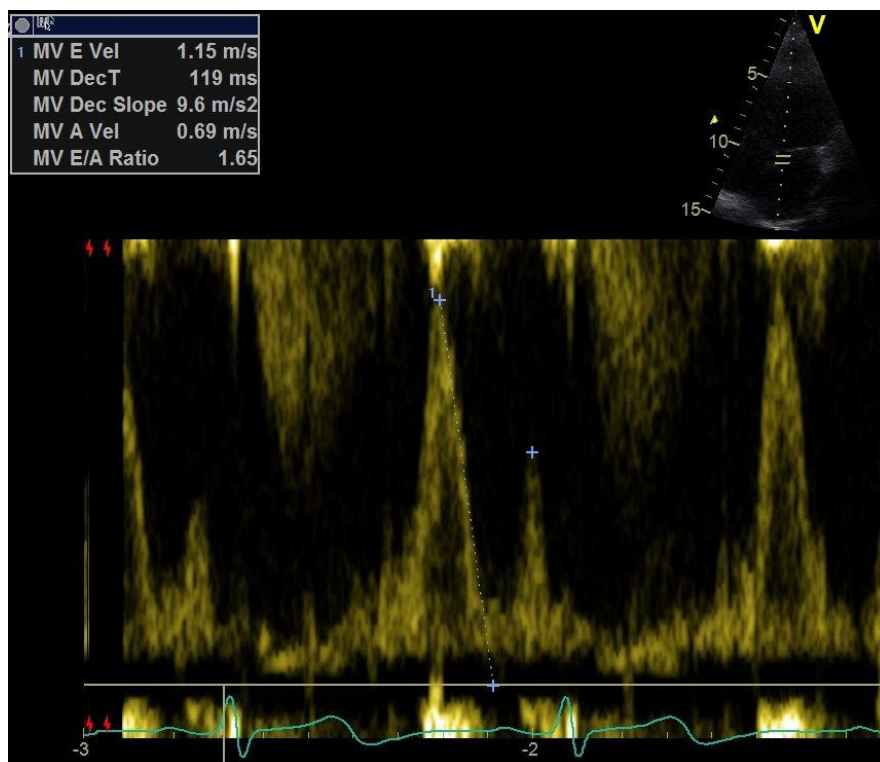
The spectral Doppler examination of the Mitral inflow (E, A, DT) from the apical four chamber view, where E is peak early diastolic mitral flow, A is peak late diastolic mitral flow and DT is deceleration time. Here first image shows imaging plane and sample volume position, and second image shows the normal spectral Doppler display.
